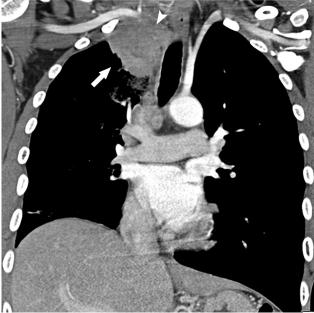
A Pancoast tumor in 52-year-old man. Coronal CT image demonstrates a right apical mass (arrow) invading into the region of the thoracic inlet. Note the invasion of the innominate vein (arrowhead). CT, computed tomography.
